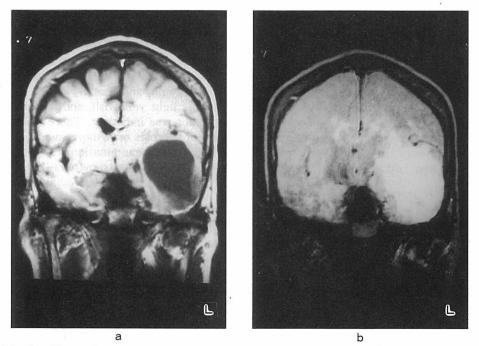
a: T1-weighted image of MRI shows left temporal large cyst and slightly hypointensity area in the lower temporal lobe. b: T2-weighted image of MRI shows hyperintensity area in the further extent to the cystic lesion.
